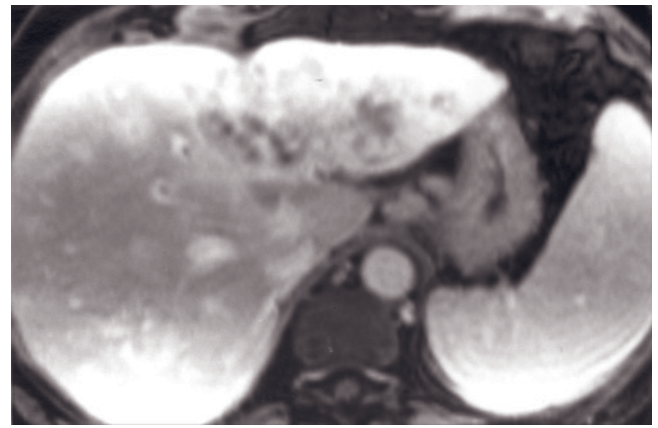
Poorly differentiated carcinoma resembling islet cell tumor. T2-weighted SS-ETSE (a, b), T1-weighted SGE (c, d), T1-weighted fat-suppressed SGE (e), immediate postgadolinium T1-weighted SGE (f, g), and 90-s postgadolinium fat-suppressed
